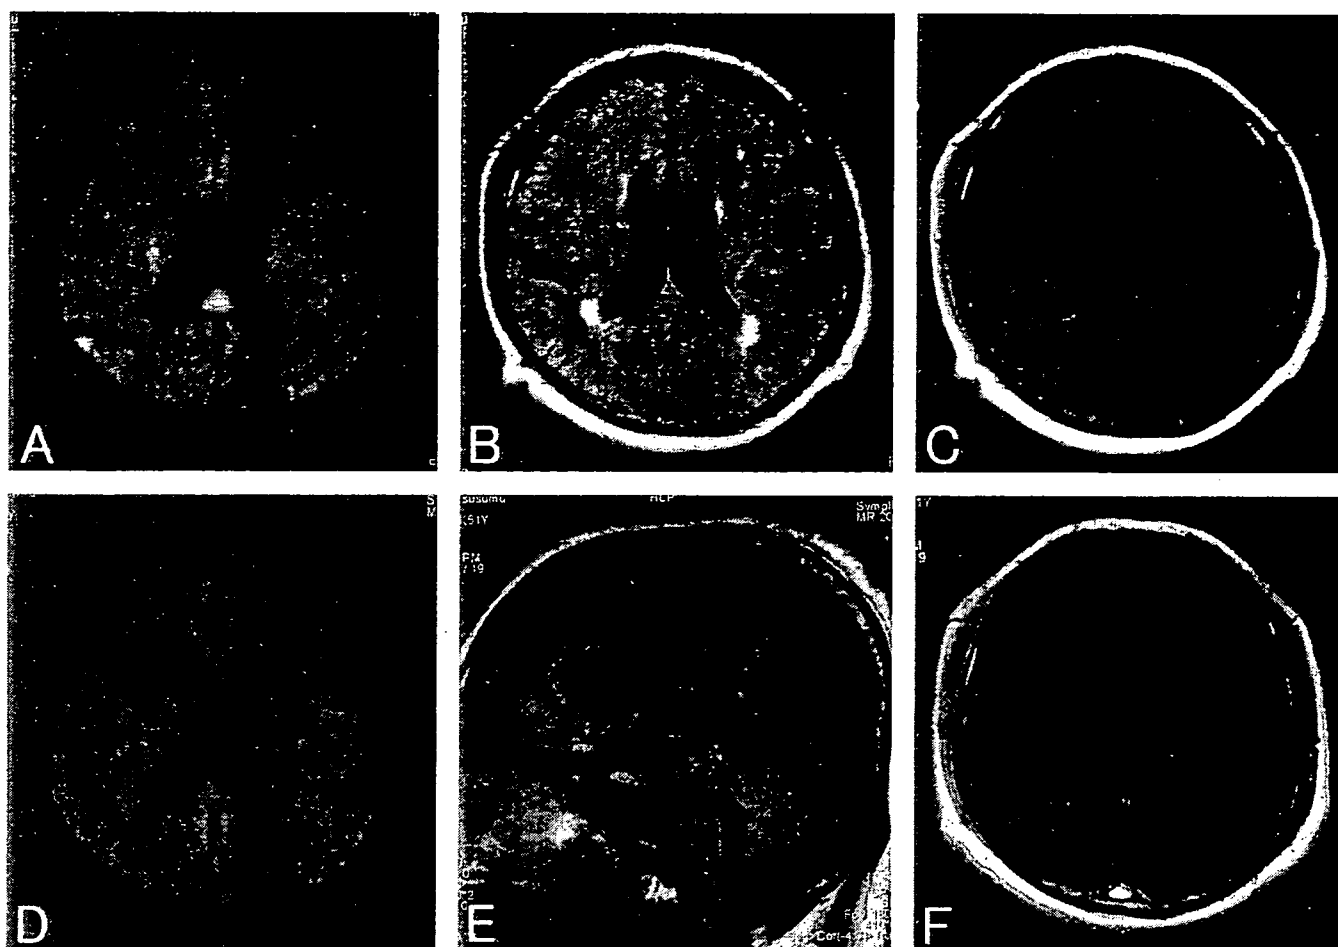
Magnetic resonance (MR) imaging on admission, showing an isolated small lesion in the splenium of the corpus callosum on diffusion-weighted image (DWI) (A), fluid-attenuated inversion recovery (FLAIR) image (B) and T1-weighted image (C). MR imaging on day 5, showing resolutions of the lesion on DWI (D), FLAIR image (E) and enhanced image after gadolinium administration (F).
